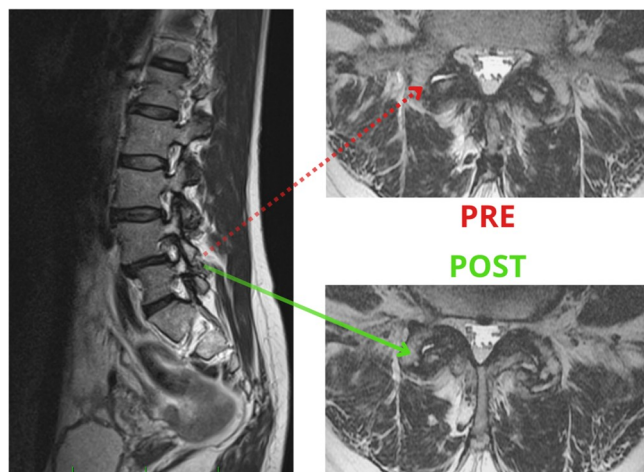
MRI findings of bone marrow edema reduction within the articular process of treated FJ L4/5, 12 months follow-up after the treatment [image from author's archive].
